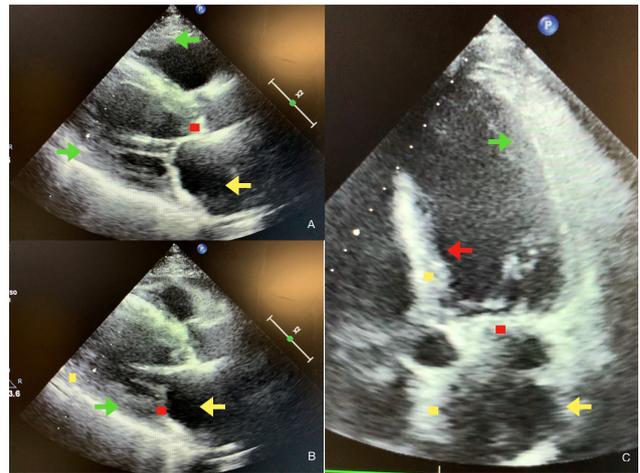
Echocardiographic features of atrial amyloidosis. Parasternal long-axis (A,B) and five chamber apical view (C) of cardiac amyloidosis (CA) and atrial amyloidosis characterized by the presence of concentric right and left ventricular thickness (green arrows in A, B, C), dilated and thickened atria (yellow arrows in A, B, C), by the thickening of the interventricular septum (red arrow in C), by sparkling spots in ventricular, atrial and septal walls (yellow dots in B, C) and by deposits in aortic and mitral valves (red dots in A, B, C).
